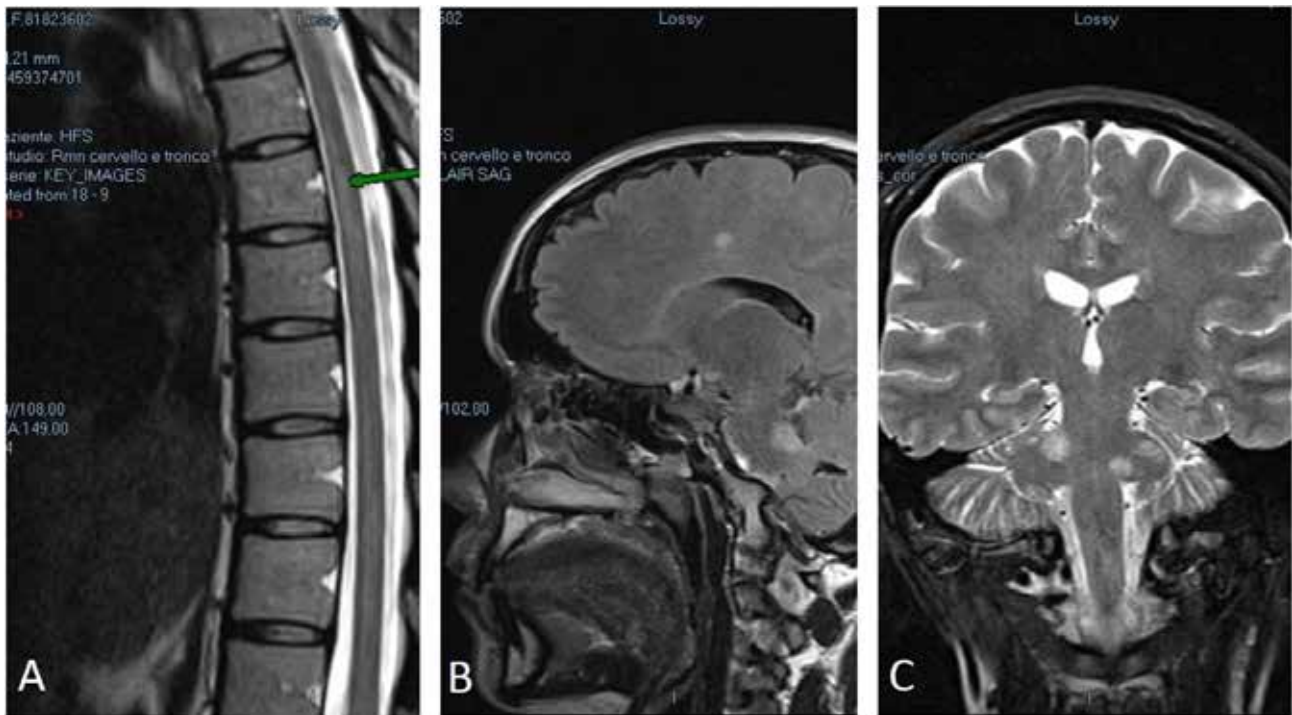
Magnetic resonance imaging during post-partum relapse. (A) New T2 lesions on D2–3. (B and C) New pericallosal and brainstem T2 lesions
